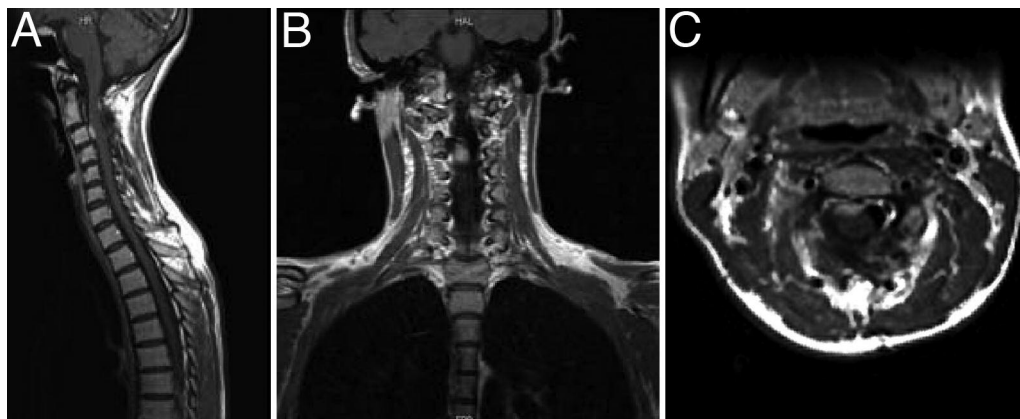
Postoperative sagittal (A), coronal (B), and axial (C) T₁-weighted MR images obtained 12 months after surgery showing signs of the tumor progressing into the subarachnoid space at the C-3 level.
